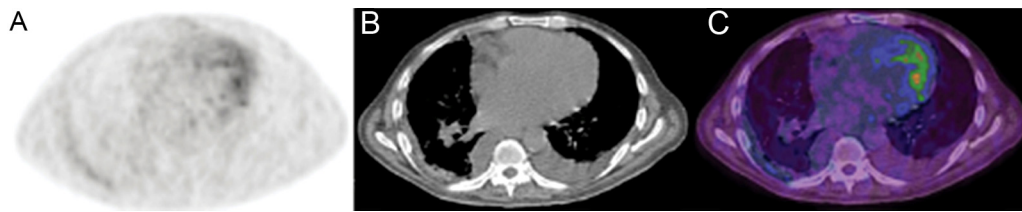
Transverse images from a 63-year-old man with NVE: (A) ^{18}F -FDG-PET-CT; (B) CT; (C) integrated ^{18}F -FDG-PET-CT. PET/CT detected no ^{18}F -FDG accumulation in the aortic valve vegetation, which was detected by TEE.
